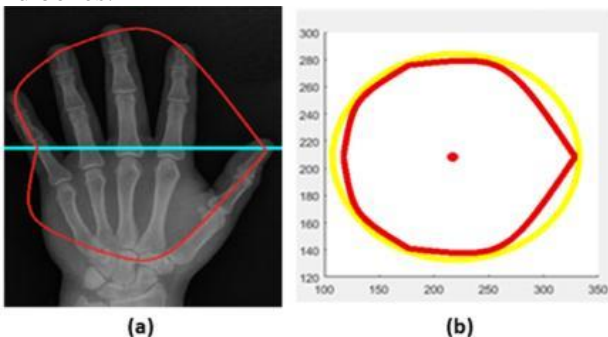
Circularity measurement for a normal radiograph: (a) enclosed polygon of a normal radiograph, (b) circularity computation result of normal radiograph
